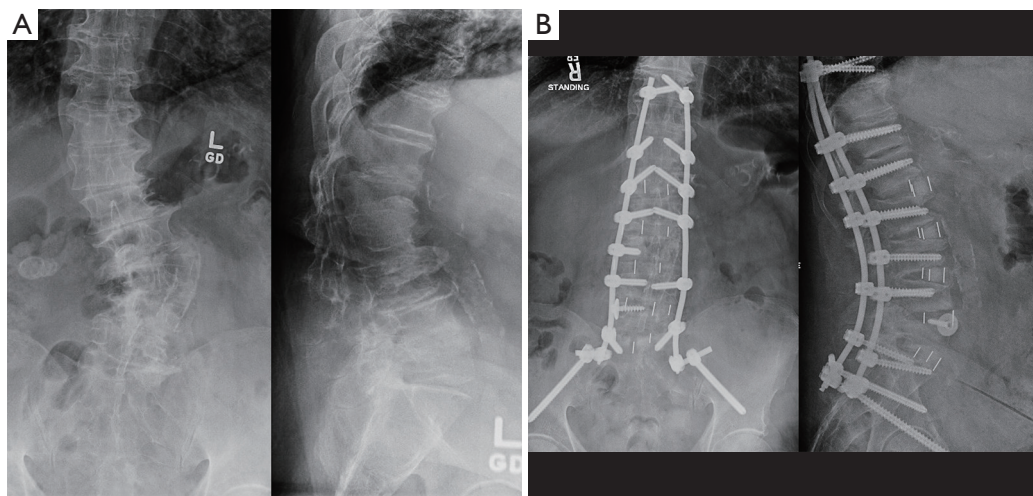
Patient case undergoing MIS-ATP + PPF long fusion. (A) Preoperative anteroposterior and lateral view X-rays demonstrating adult degenerative scoliosis. (B) Anteroposterior and lateral view X-rays of a MIS-ATP long spinal fusion with pelvic fixation. Permission use request was granted by Wolters Kluwer Health, Inc. (license: 5726840365092). MIS-ATP, minimally invasive surgery antepsoas; PPF, posterior percutaneous fixation.
